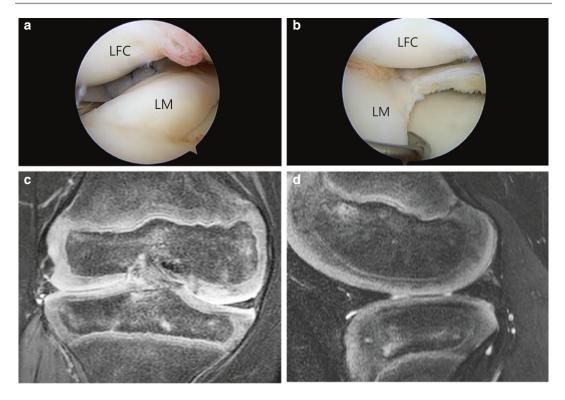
a The 30° arthroscope inserted from anterolateral portal also shows anatomic coaptation of the lateral meniscus posterior horn tear with 3 vertical sutures. b After partial meniscectomy with repair, peripheral rim of lateral meniscus was preserved with 8-10 mm that is the similar size of the midbody of medial meniscus. c, d coronal and sagittal magnetic resonance imaging shows complete healing of the tear site with a lateral meniscus of normal shape at 6 months' follow-up. (LFC, lateral femoral condyle; LM, discoid lateral meniscus)
